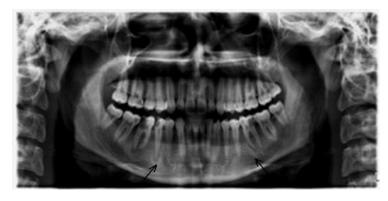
Panoramic radiograph showing two COLs at right mandibular second premolar and left mandibular first molar in a one patient
